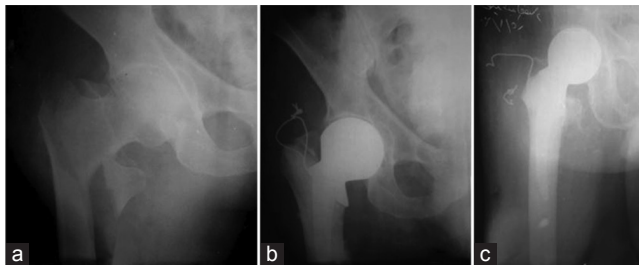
77-year-old woman with Evan type IV unstable intertrochanteric fracture of the left hip. (a) Preoperative radiograph (anteroposterior view). (b) One month after primary hemiarthroplasty (anteroposterior radiograph). The lesser trochanter fragment could not be reduced, and its defect was reconstructed using cement. (c) Three-year follow-up (lateral radiograph). Patient's final outcome was graded as fair.
